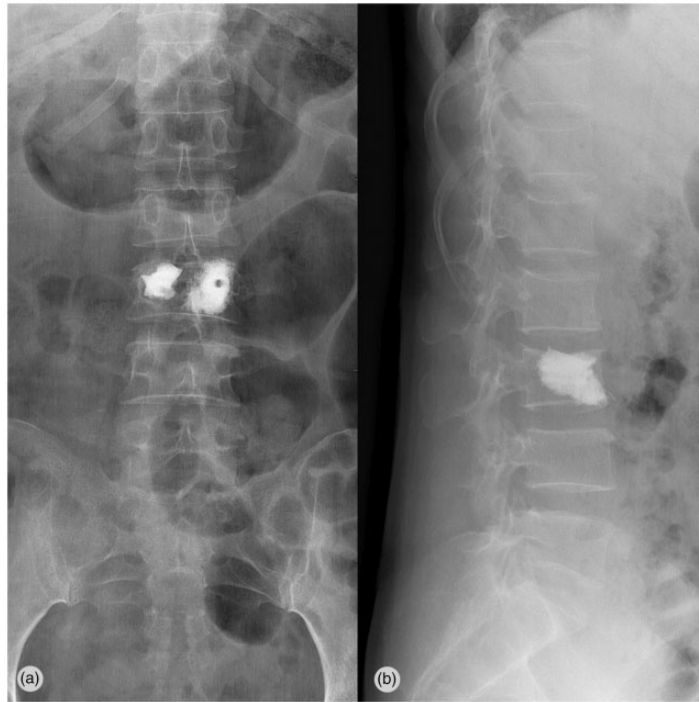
Postoperative anteroposterior and lateral radiographs show good filling of bone cement after L3 PKP. PKP, percutaneous kyphoplasty.
